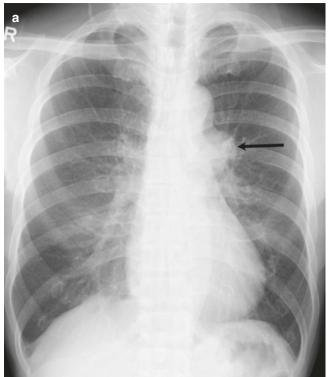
51-year-old woman with goiter. (a) Frontal radiograph shows widening of the left paratracheal stripe (arrows) with displacement of the trachea toward the right. (b) Coronal CT confirms the retrosternal extension of the left lobe of thyroid (arrow)
